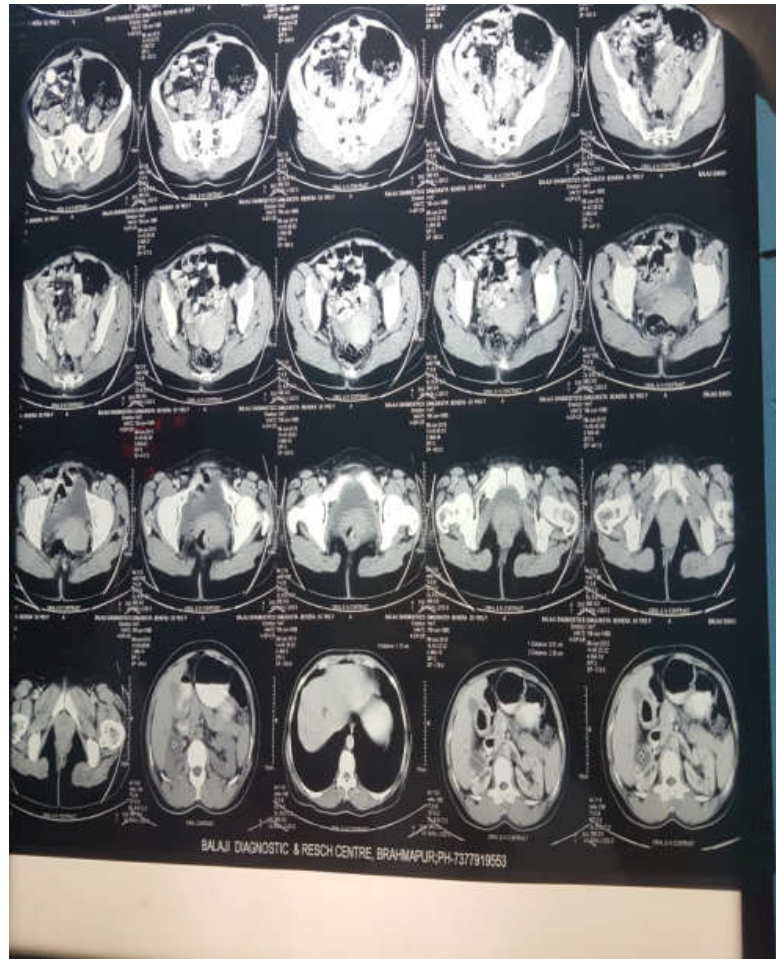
CT scan Abdomen showing multiple cysts in liver, kidneys
